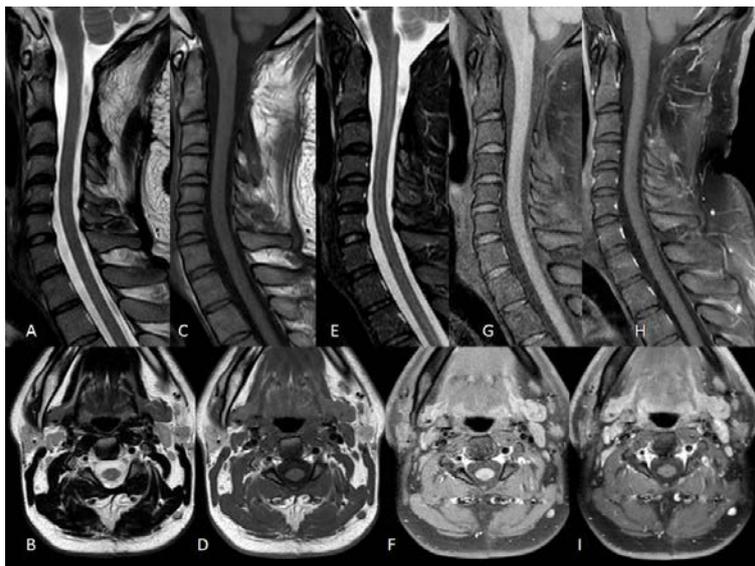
Postoperative cervical spine MRI. Sagittal and Axial T2WI (A,B); T1WI (C,D) ; STIR (E,F); T1FS (G); T1FS+C (H,I) – Shows post-operative appearance with C2 level laminectomy and status-post excision of the cystic lesion
